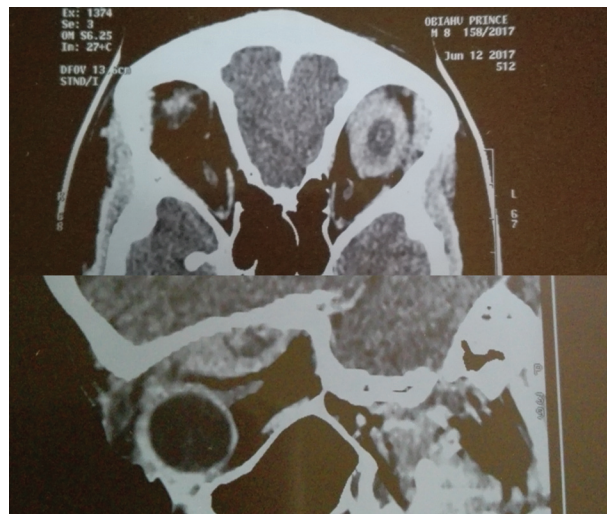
Characteristic appearance of cysticercosis on computed tomography scan
